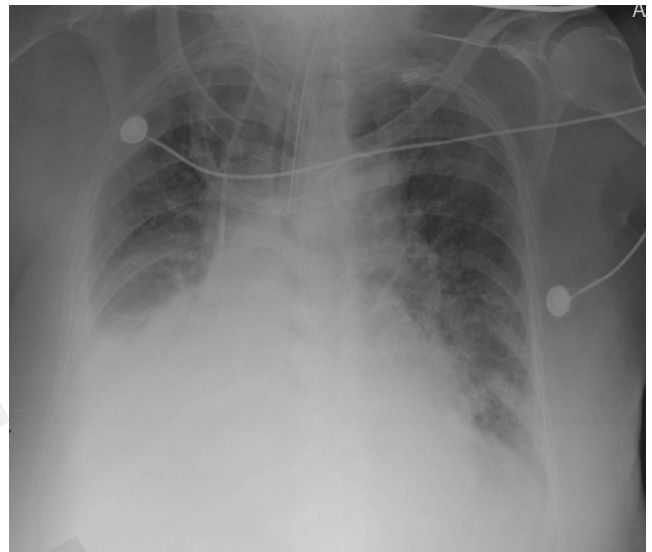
Chest radiographs with visible fluid in the right costodiaphragmatic recess. X-ray taken on day of admission to the ICU
